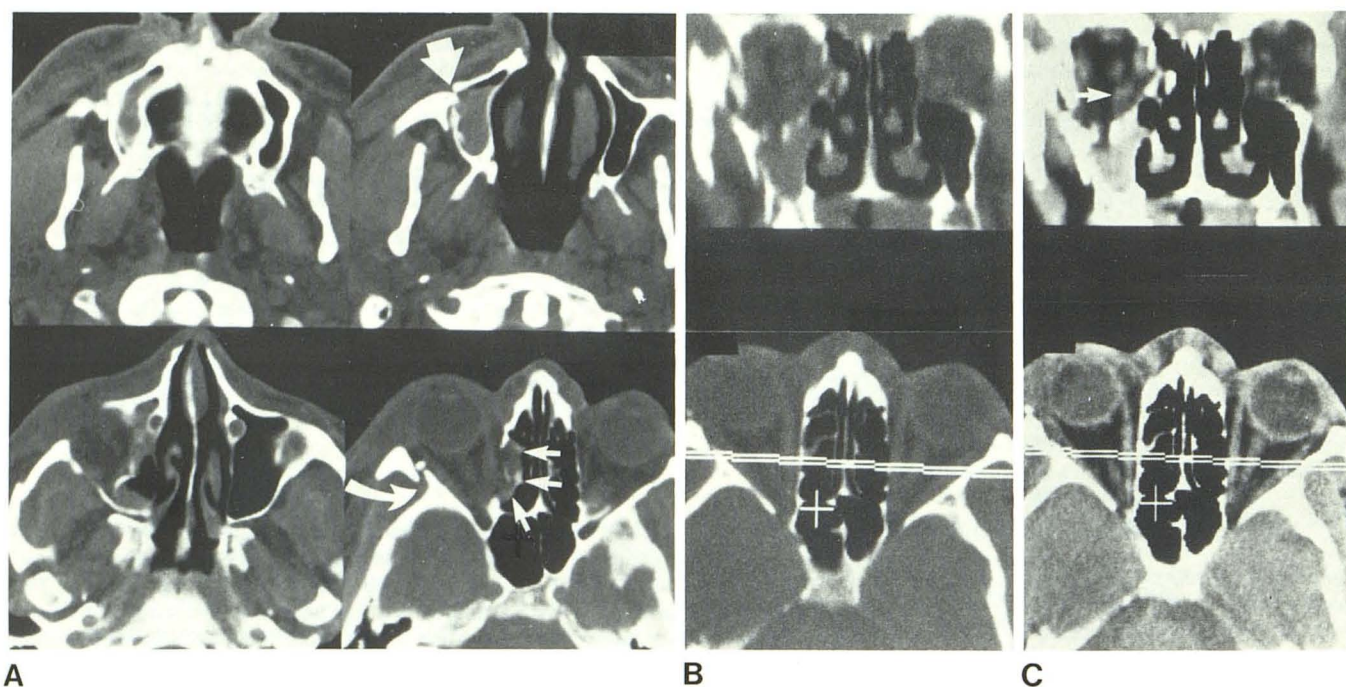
Tripod fracture of right maxilla. A, Sequential axial CT sections. Posteroinferior separation of zygoma from right maxilla (*large arrow*); fractures of zygomatic arch, frontozygomatic suture (*curved arrow*), and medial
